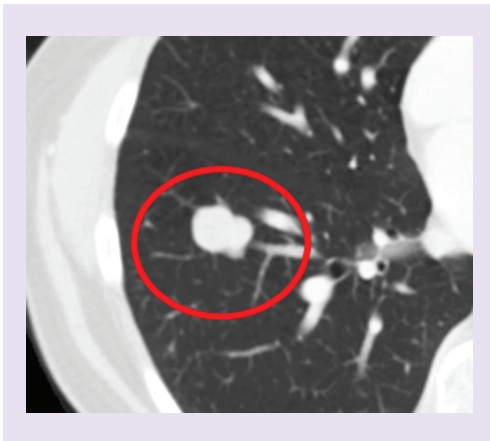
CT scan showing disease progression (January 2012).
